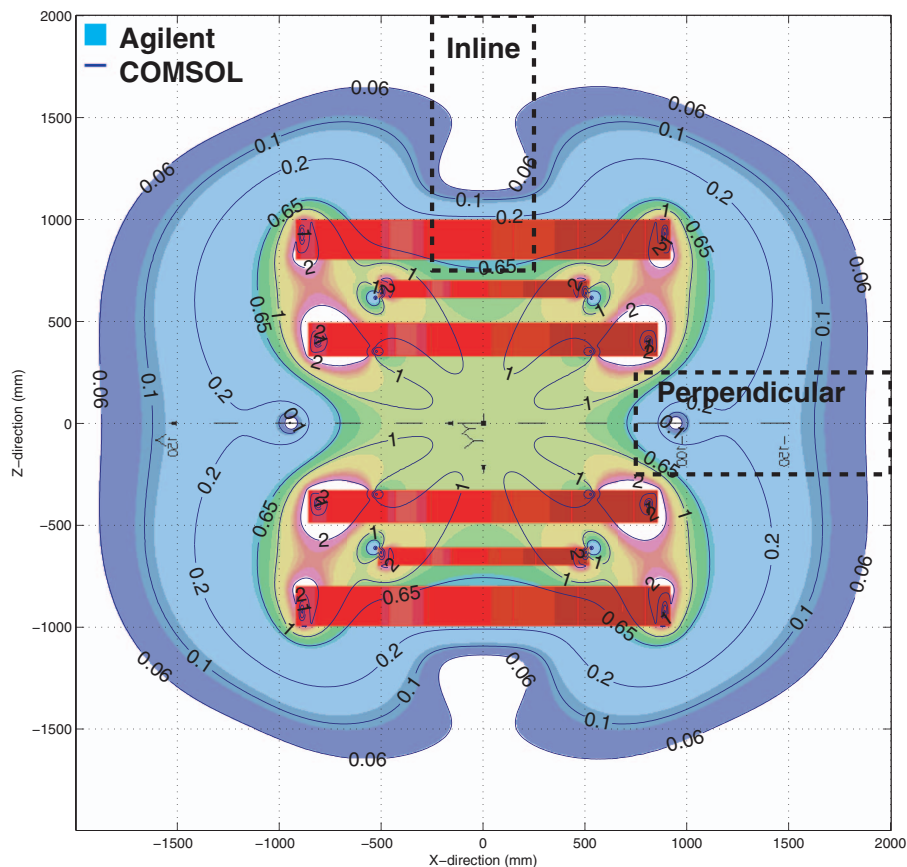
Magnetic field magnitude map of the Agilent 1 T MRI design (fill plot) and COMSOL (contour plot) match in the central x-z plane. Current coils are shown in red and below 0.06 T or above 2 T is shown as white. The agreement seen between our COMSOL results and the Agilent data is  $\pm 0.0001$  T inside the DSV. Also shown is the low magnetic field regions for positioning of the linac in either the perpendicular or inline orientation.
